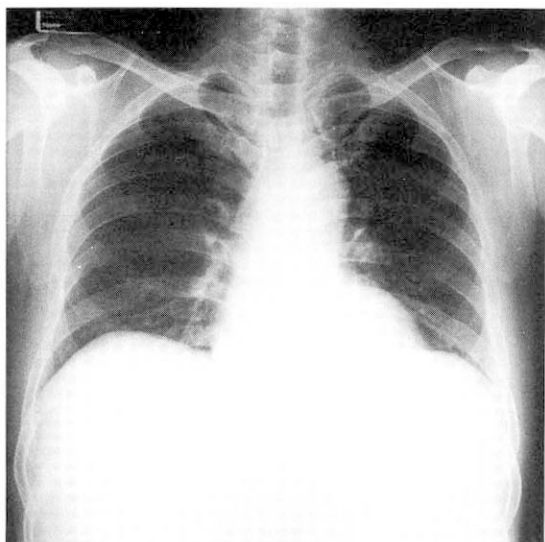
Chest radiograph on admission shows normal findings.
